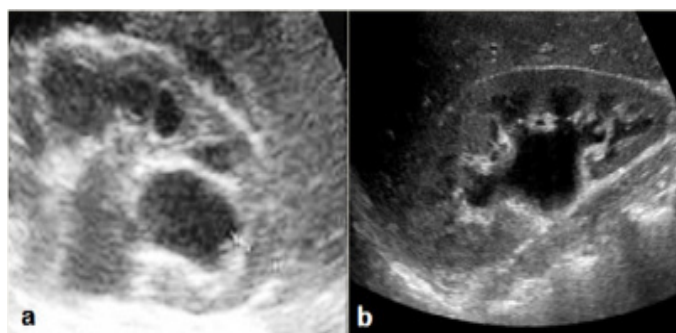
Sonographic appearance of Hydronephrotic tuberculous kidney.
